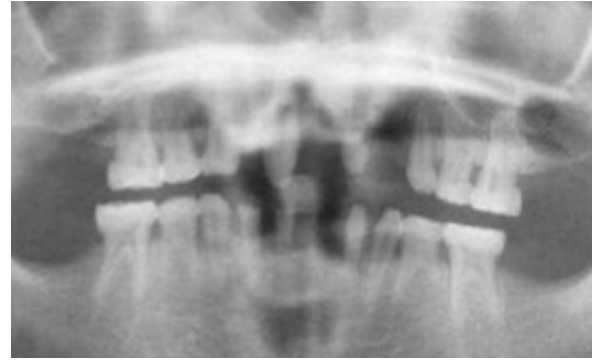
Panoramic radiograph was taken to find out whether or not permanent teeth germs were exist .
